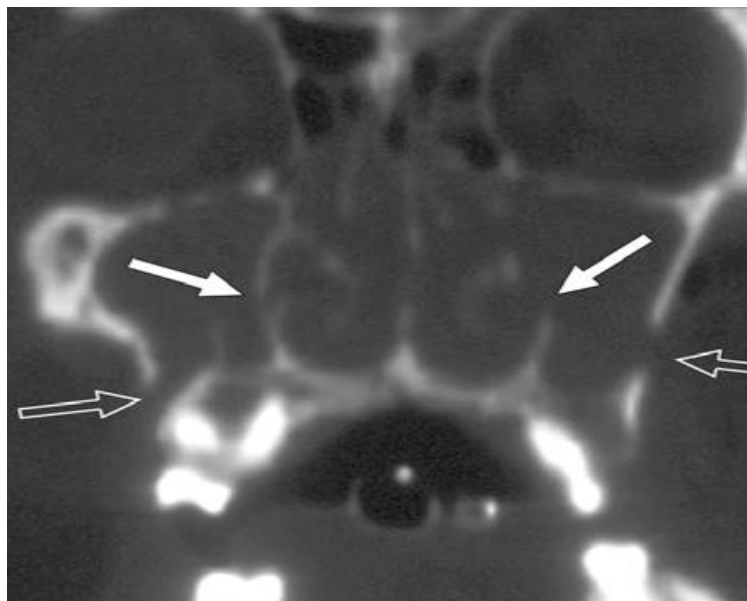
A, Coronal CT image shows bilateral fractures of pterygoid processes (*arrows*).
